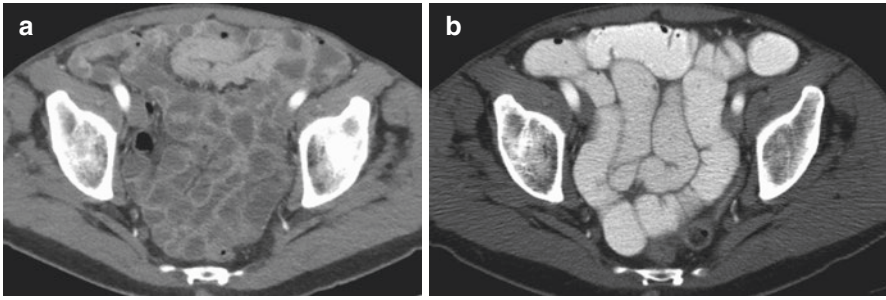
CT enterogram using low-density barium sulfate suspension (a) and standard barium solution (b). In image (a), mural and mucosal enhancement is readily identifiable with neutral oral contrast while much less conspicuous in image (b) due to the positive oral contrast
